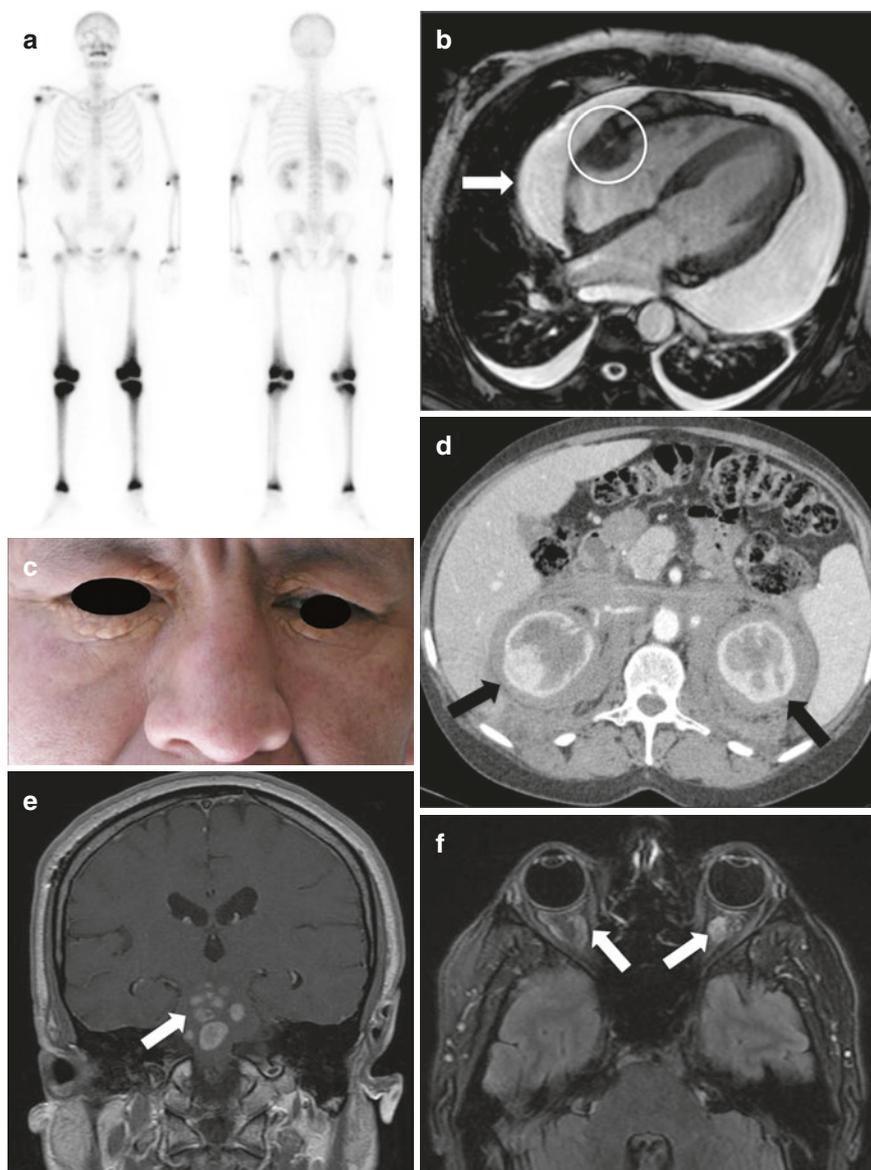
Typical clinical and imaging findings in ECD. (a) ^{99}Tc Bone scintigraphy showing bilateral and symmetric tracer uptake of the distal femurs and of the proximal and distal tibias. (b) Cardiac magnetic resonance (MR) scan showing massive pericardial effusion (*arrow*) and infiltration of the right atrium (*circle*). (c) Bilateral xanthelasmas involving the upper and lower eyelids. (d) Abdominal computed tomography scan showing retroperitoneal infiltration, around the kidneys (*arrows*) but also involving the abdominal aorta and the renal arteries. (e) Brain MR (coronal view) showing multiple lesions involving the encephalic trunk (*arrow*). (f) Brain MR (axial view) showing bilateral infiltration of the retro-orbital space (*arrows*).
